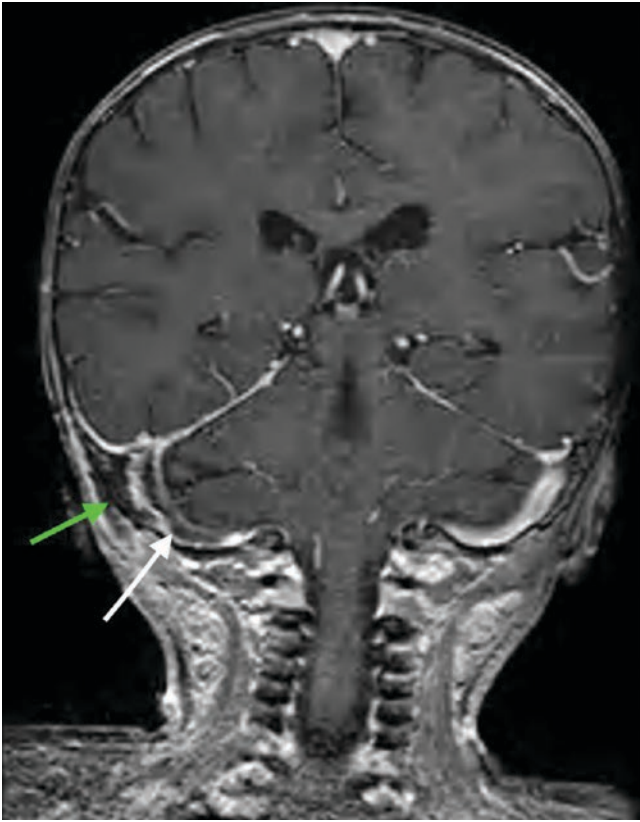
Right mastoiditis complicated by thrombophlebitis. Coronal post-contrast T1-weighted fat-saturated MR image demonstrates thrombus within the right sigmoid sinus (*white arrow*) and an adjacent epidural abscess (*green arrow*)
